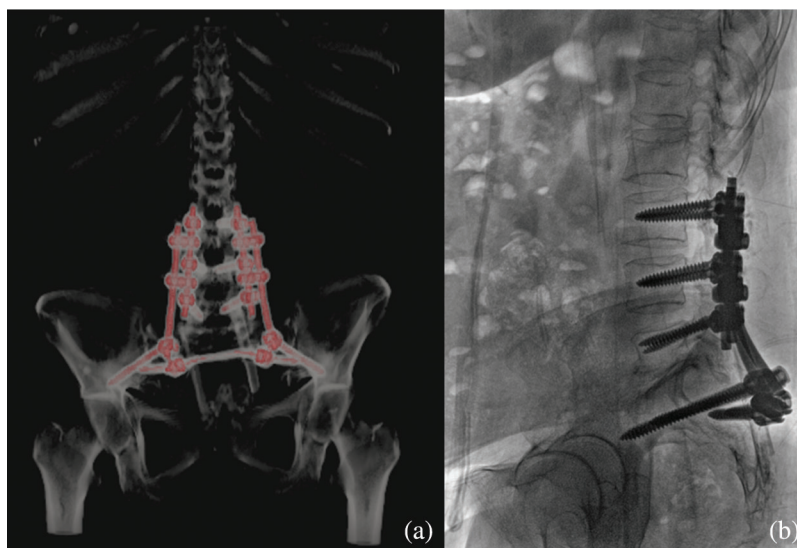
(a) 3D reconstruction of the postoperative CT scan showing the adequately placed polyaxial screws achieving lumbo-iliac fixation. (b) Absence of greater sciatic notch breach on the lateral plain radiograph
